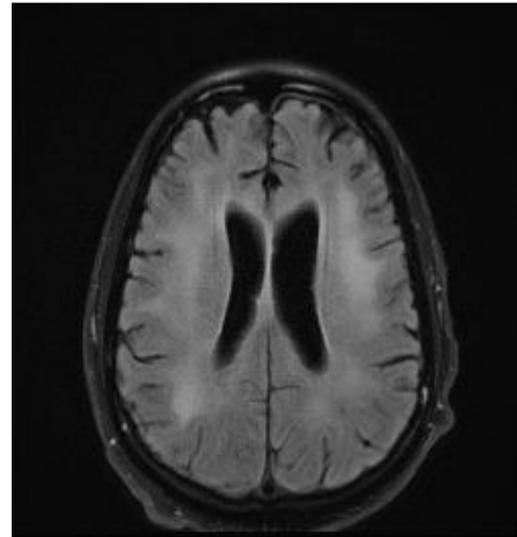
An MRI of the brain with and without contrast showing nonspecific, patchy, and confluent hypoattenuation in the periventricular and subcortical white matter.
